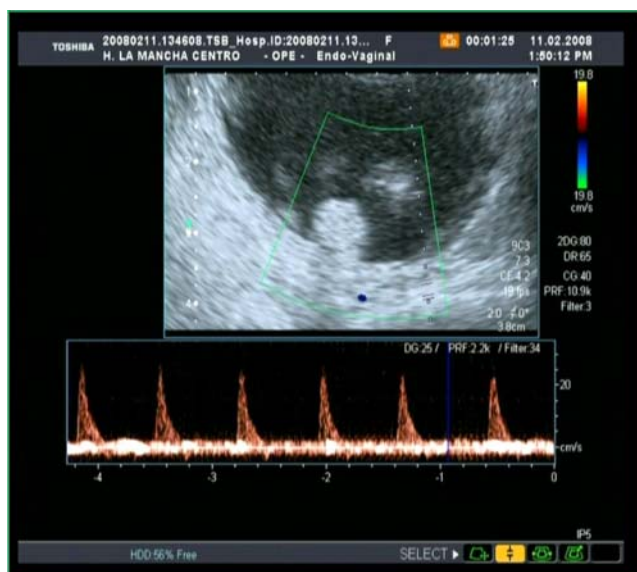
Vaginal ultrasound of right ovary
